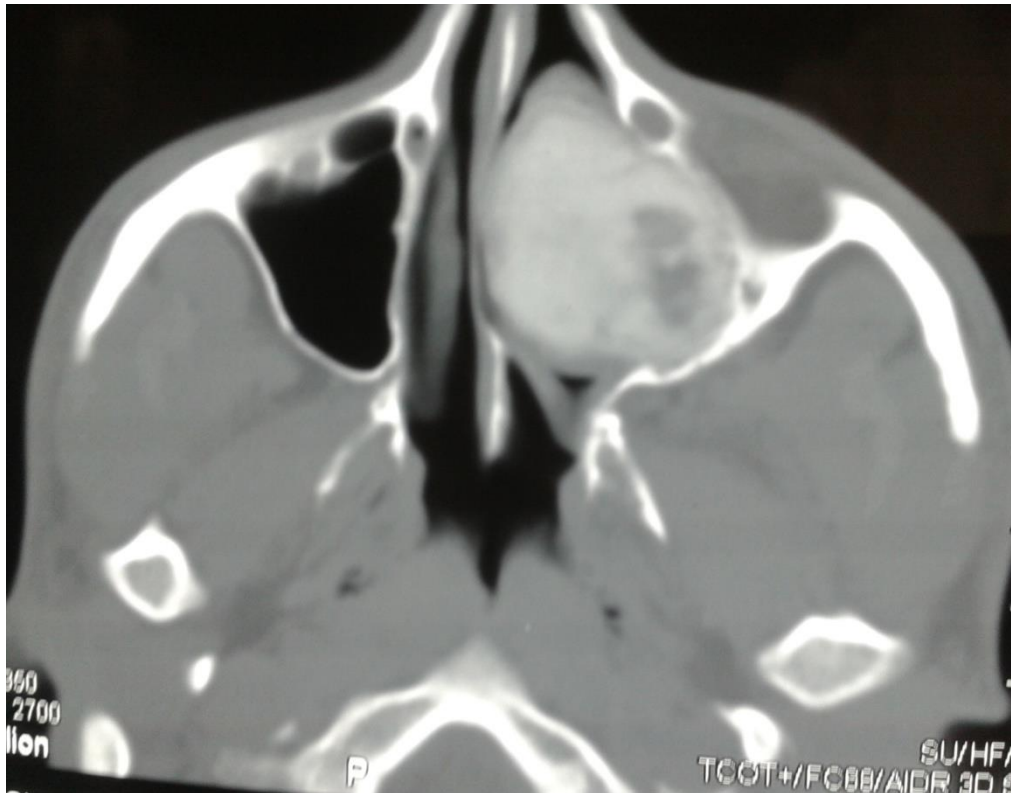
Fibrous dysplasia. Axial CT image in bone window shows hyperdense bony lesion seen in left maxillary sinus. (en.wikipedia.org/wiki/Maxillary sinus disease)
